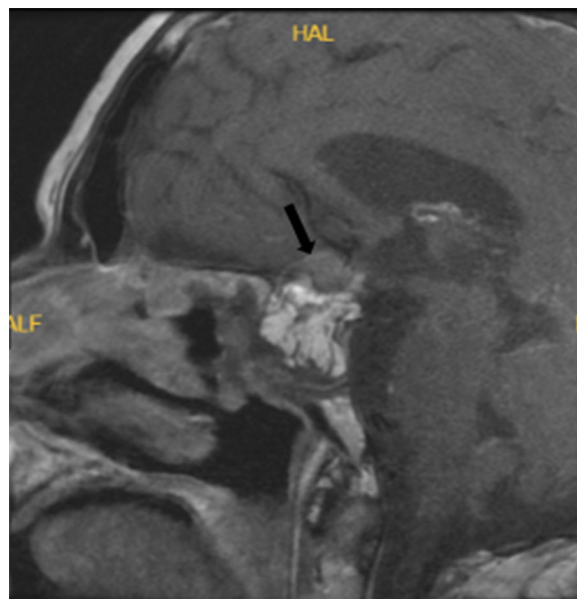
Postoperative T1-weighted contrast enhanced pituitary MRI showed heterogeneous internal high-intensity signals indicating fat packing of the sphenoid sinus and tumor residue (black arrow)
